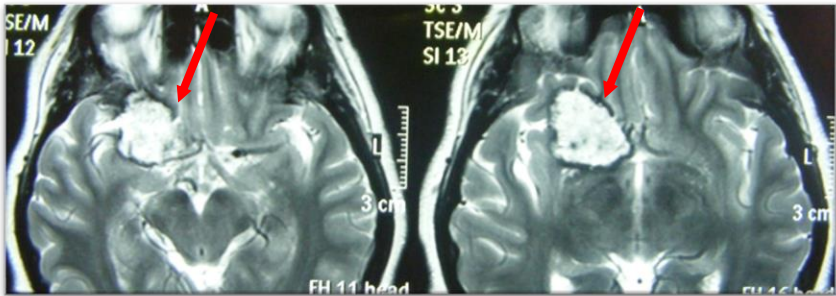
Axial MRI: Right fronto-temporo-insular cavernoma
